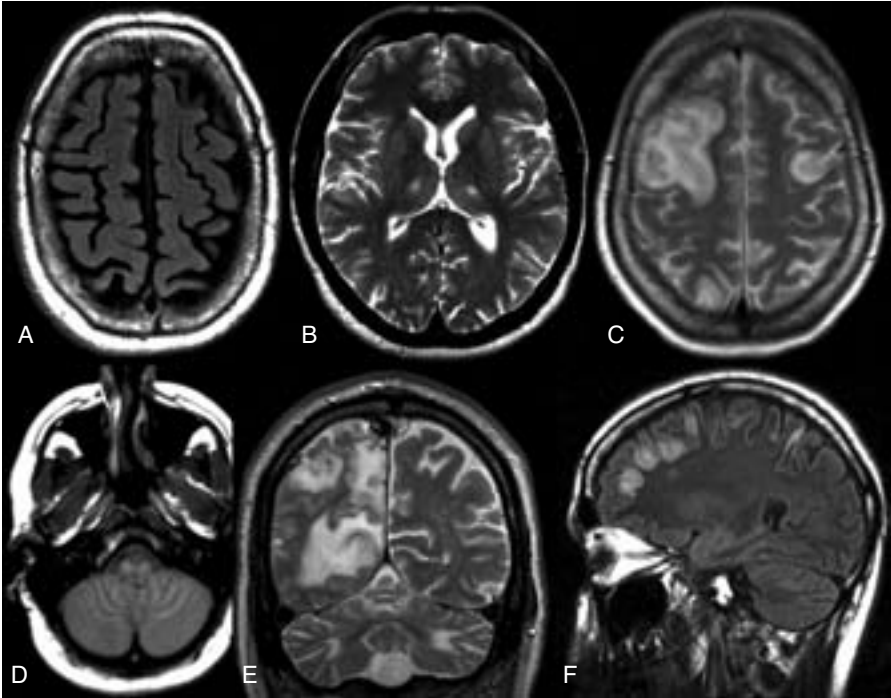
Common MRI findings in MSCAE. A: axial T2 FLAIR image showing cerebral atrophy. B: axial T2 image showing bilateral thalamic lesions. C: axial T2 image showing cortical lesions in both frontal lobes and the right parietooccipital area. D: axial proton weighted image showing bilateral olivary lesions. E: coronal T2 image showing a right occipital lesion and bilateral white matter hyperintensity in the cerebellum. F: sagittal T2 FLAIR image showing widespread frontal cortical lesions.
